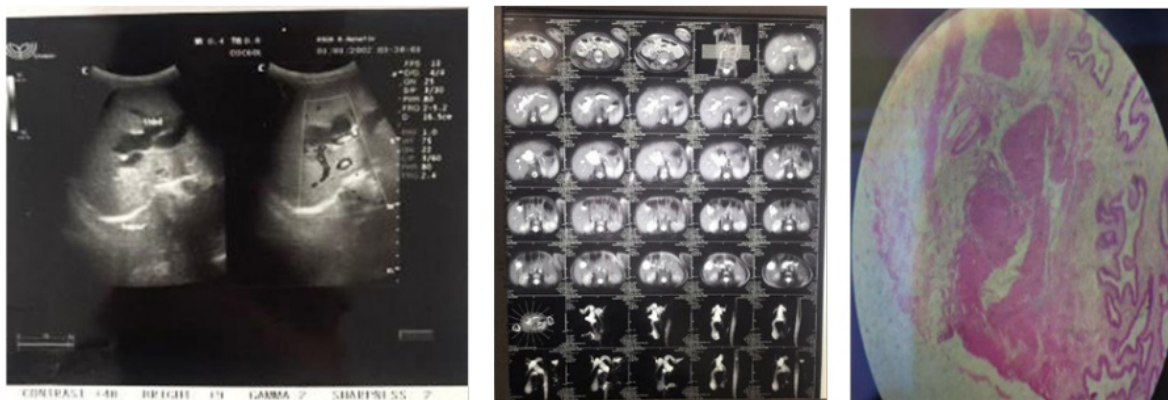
Abdominal ultrasound, MRI- MRCP and Pathology anatomy
